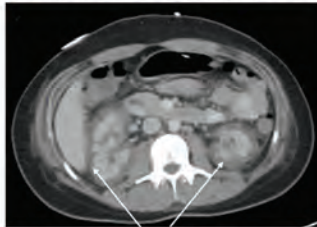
Post-op contrast CT abdomen&pelvis: Diffuse hypodensity of bilateral renal cortex in relation to the medullary pyramids. No hydronephrosis. No stones.
